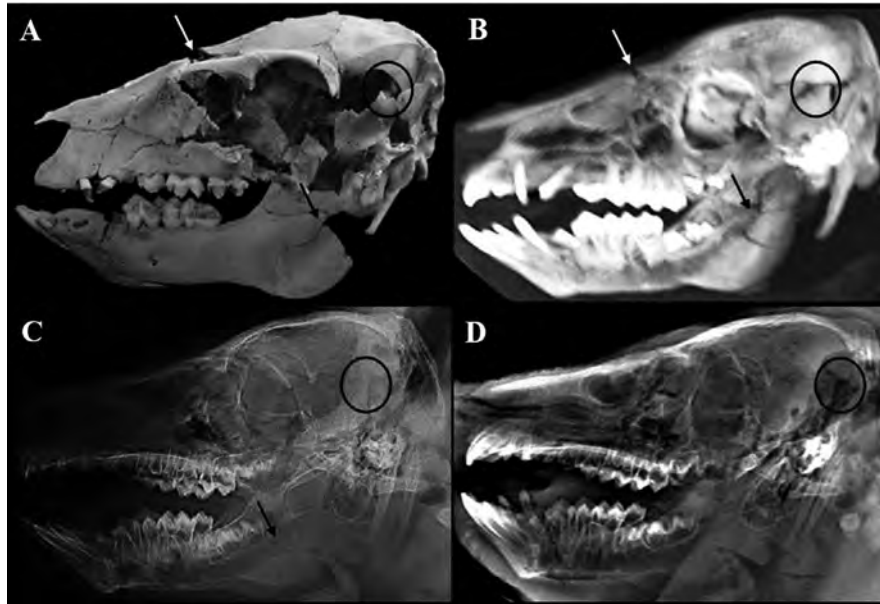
Parietal complex fracture (black circle) as seen on dry bone (A), CT (B), X-ray (C), and Lodox[®] (D). A fronto-nasal diastatic fracture (white arrow) is seen on dry bone (A) and CT (B), but not on X-ray (C) and Lodox[®] (D). A complex mandibular ramus fracture (black arrow) is also seen on dry bone (A) and CT (B), but is classified as simple linear on X-ray (C) and not visible on Lodox[®] (D)
